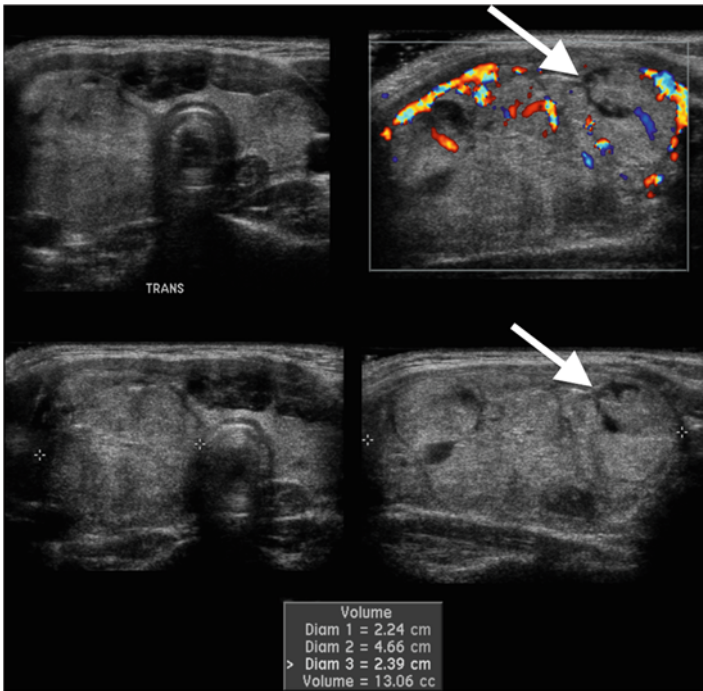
Papillary carcinoma. Transverse (*top left & bottom left*) and longitudinal color Doppler (*top right*) and grayscale (*bottom right*) US images show a large, heterogeneous, multilobulated mass (*calipers*) almost replacing the entire right lobe of the thyroid in a 12-year-old boy. There is focal extracapsular extension (*arrows*) of this papillary carcinoma.
